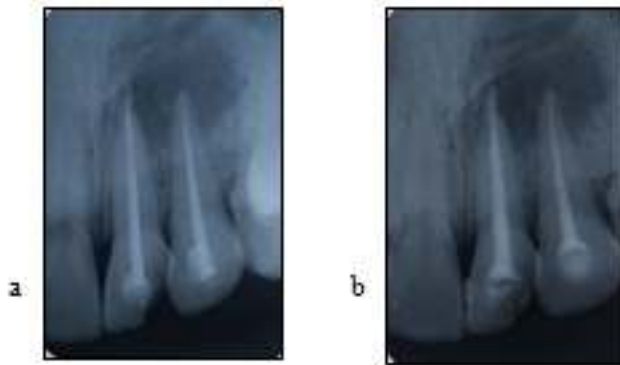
(a).Master cone 21,22 radiograph. (b). Obturation 21,22 radiograph
